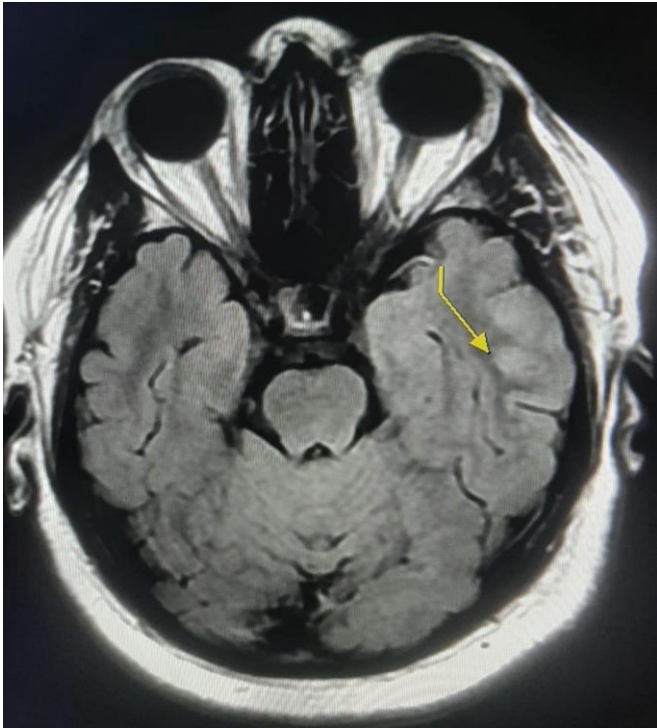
1 MRI Brain shows Acute infaction left temporal, Bilateral basalgenglia and centrum semiovale and left parietal area.
